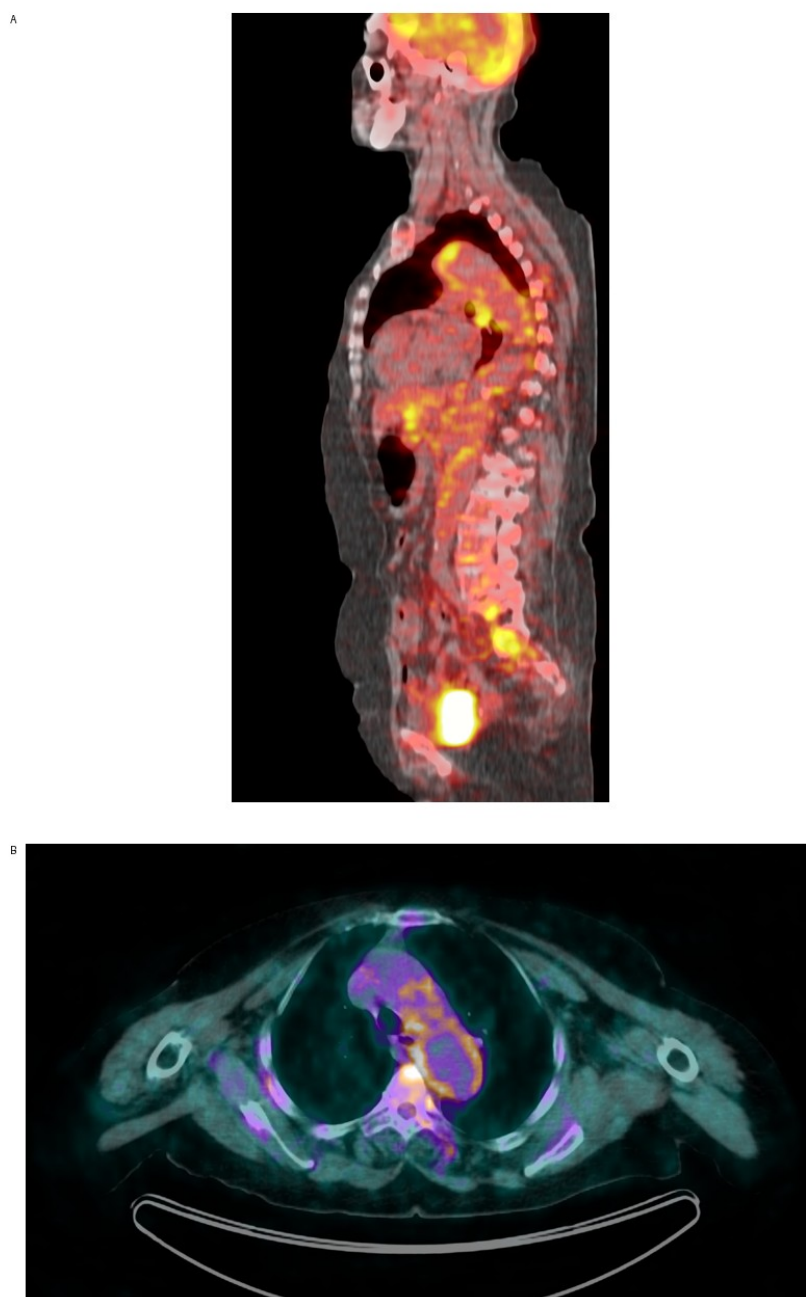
18F-FDG PET/CT. (A) Sagittal fused PET/CT image demonstrating increased FDG uptake along the thoracic and abdominal aorta. (B) Axial fused PET/CT image at the level of the thoracic aorta demonstrating prominent mural FDG uptake.
